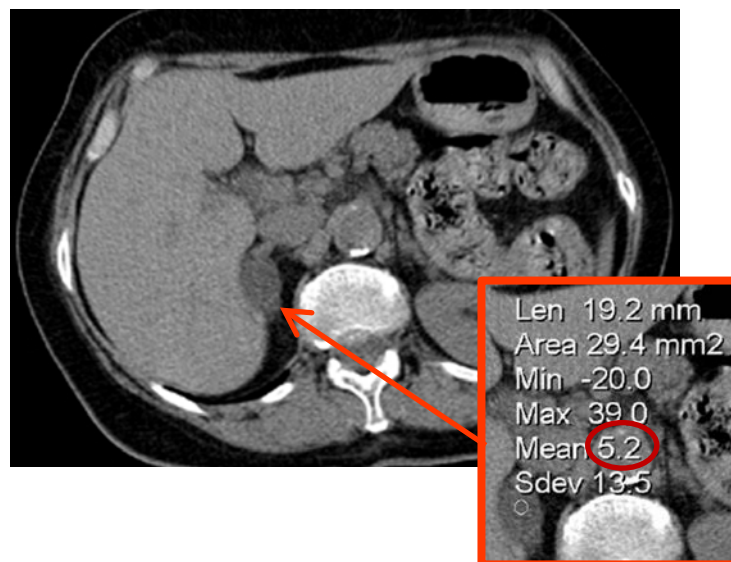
Unenhanced CT with right adrenal incidentaloma, mean attenuation = 5.2 HU, in keeping with a lipid-rich adenoma
